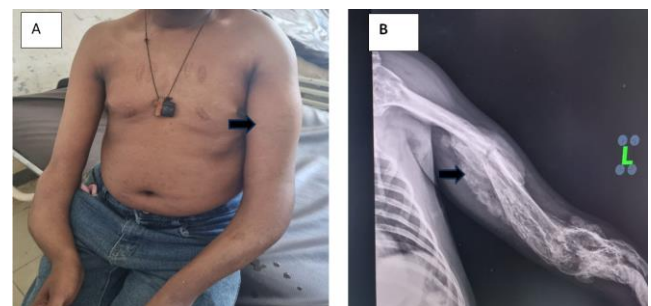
(A) Clinical photography showing swelling over his right distal arm and forearm, left arm (arrow) and forearm. (B) X-ray of the left arm showing left humerus healed fracture and ossification of soft tissue surrounding the humerus (arrow).
